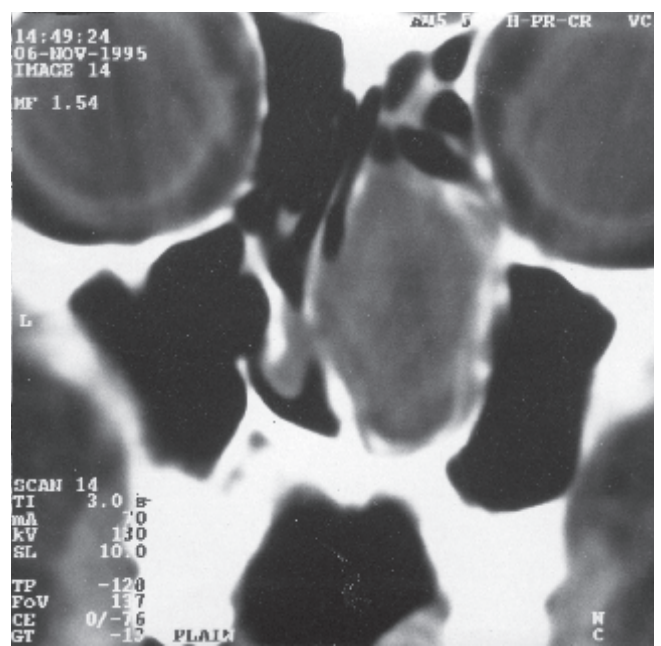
Coronal CT showing the mass completely filling the right nasal fossa and pushing the nasal septum to the left side.
